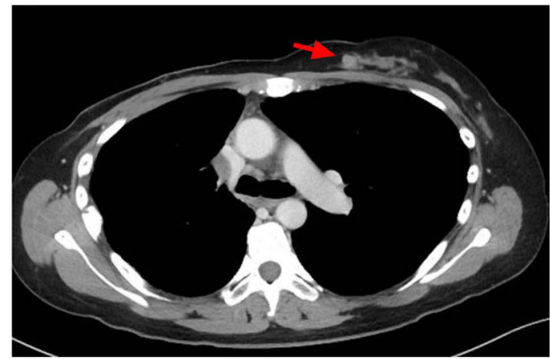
Chest computed tomography revealed nodules (red arrows) in the left breast.
